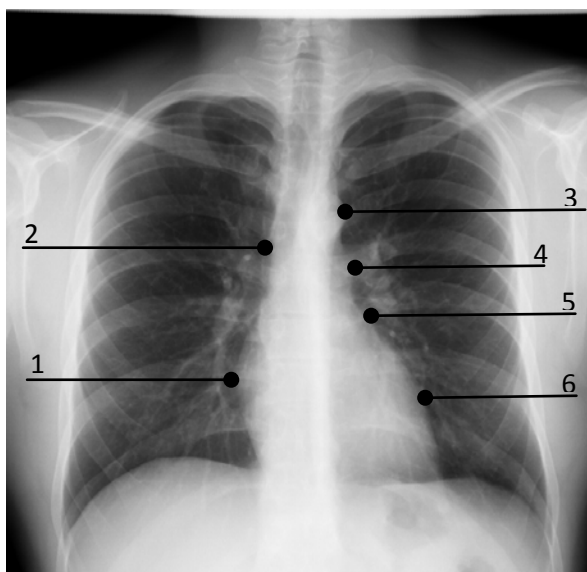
Chest radiograph. Frontal view. 1– right atrium; 2 – ascending aorta; 3 – arch of aorta; 4 – trunk of pulmonary; artery; 5 – left atrium; 6 – left ventricle. See also text. Norm
